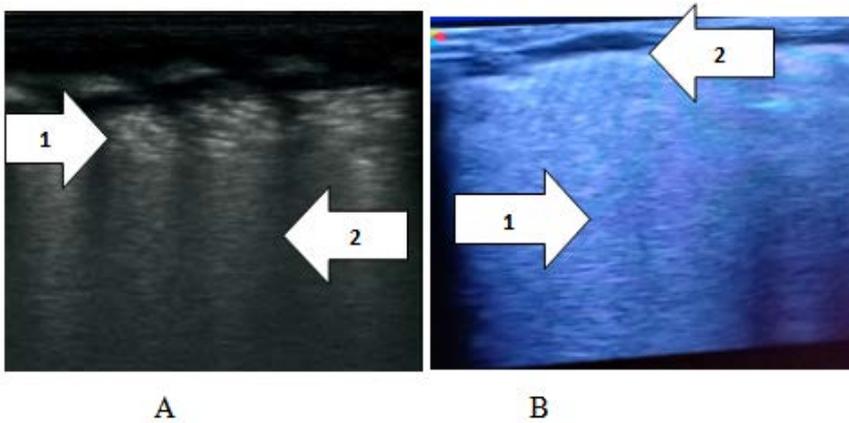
A) Chest ultrasound for RDS patient showing absent A lines, regular consolidations with air bronchogram (Arrow 1) and intervening alveolar interstitial syndrome (AIS) (Arrow 2). B) Chest ultrasound of RDS case showing compacted B-lines (Arrow 1) and pleural line abnormalities (Arrow 2).
